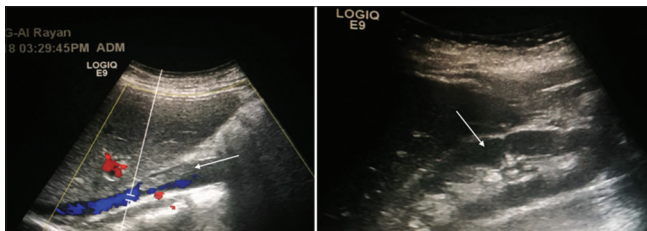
Ultrasound abdomen showed large floating thrombus in the juxtarenal inferior vena cava, see arrow. There is evidence of the right kidney congestion suggestive of pyelonephritis with perinephric fluid collection, see arrow
